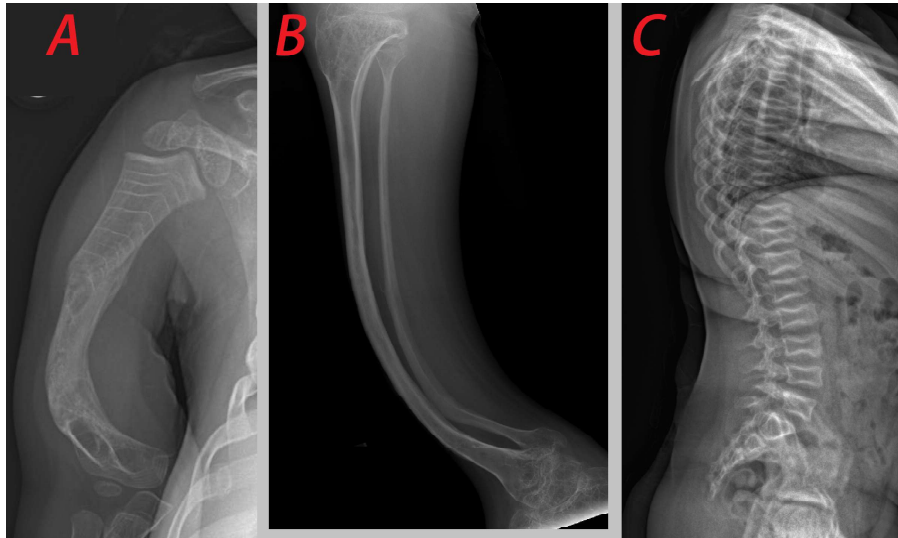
A) Anteroposterior radiographic view of the right humerus in a patient with osteogenesis imperfecta. Note the severe bowing deformity present. Also noticeable are multiple growth arrest lines in the proximal half of the humerus. B) Lateral radiographic view of the tibia in a patient with osteogenesis imperfecta. Note the anterior bowing of the tibia, the so-called “saber shin” deformity. C) Lateral radiographic view of the spine of a patient with osteogenesis imperfecta. Note the biconcave appearance of multiple vertebral bodies due to multiple compression deformities over time. This appearance is termed “codfish vertebrae.”
